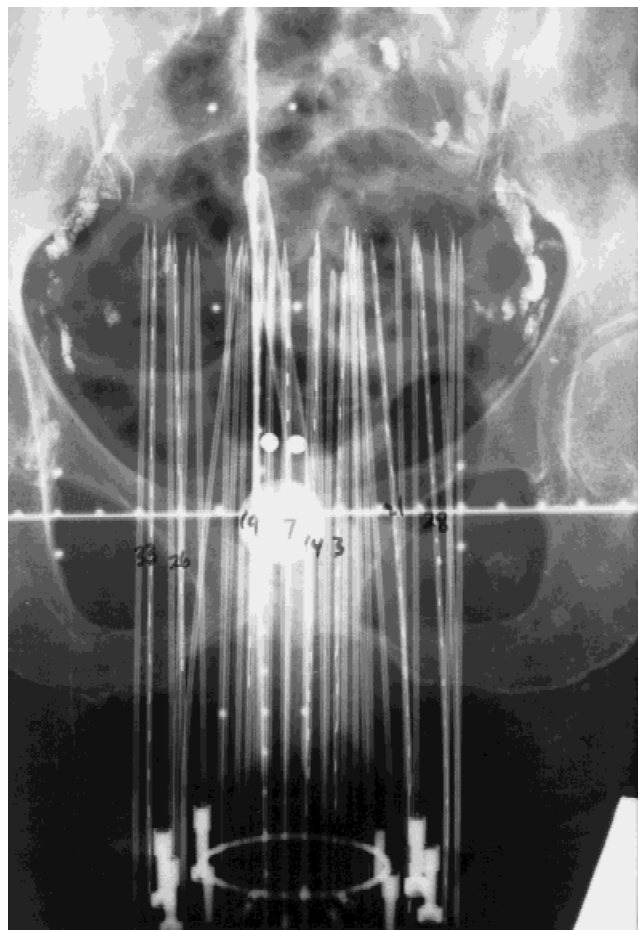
AP radiograph Syed-Neblett template, needles, and tandem. Note: Cervical marker balls above bladder catheter bulb. "Dummy" sources are in several central and peripheral needles. (Reprinted, with permission from Erickson B, Albano K, Gillin M: CT guided interstitial implantation of gynecologic malignancies. *International Journal of Radiation Oncology • Biology • Physics* 1996;36:699–709. Elsevier Science Inc.)
